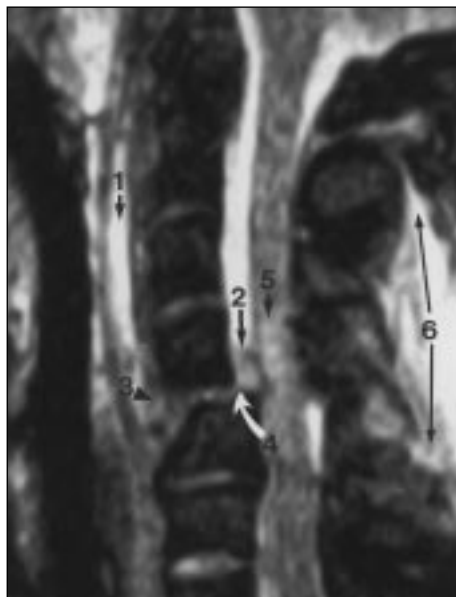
Bilateral interfacetal dislocation at C4-5 in 62-year-old man involved in motor vehicle crash. Sagittal gradient-echo MR image (TR/TE, 510/35; flip angle, 20°) obtained on 0.3-T MR scanner shows prevertebral edema or hemorrhage (1), posterior longitudinal ligament tear (2), anterior longitudinal ligament tear (3), large traumatic posterior disk extrusion (4), cord contusion and compression (5), posterior paravertebral edema or hemorrhage, and probable interspinous ligament injury (6).
